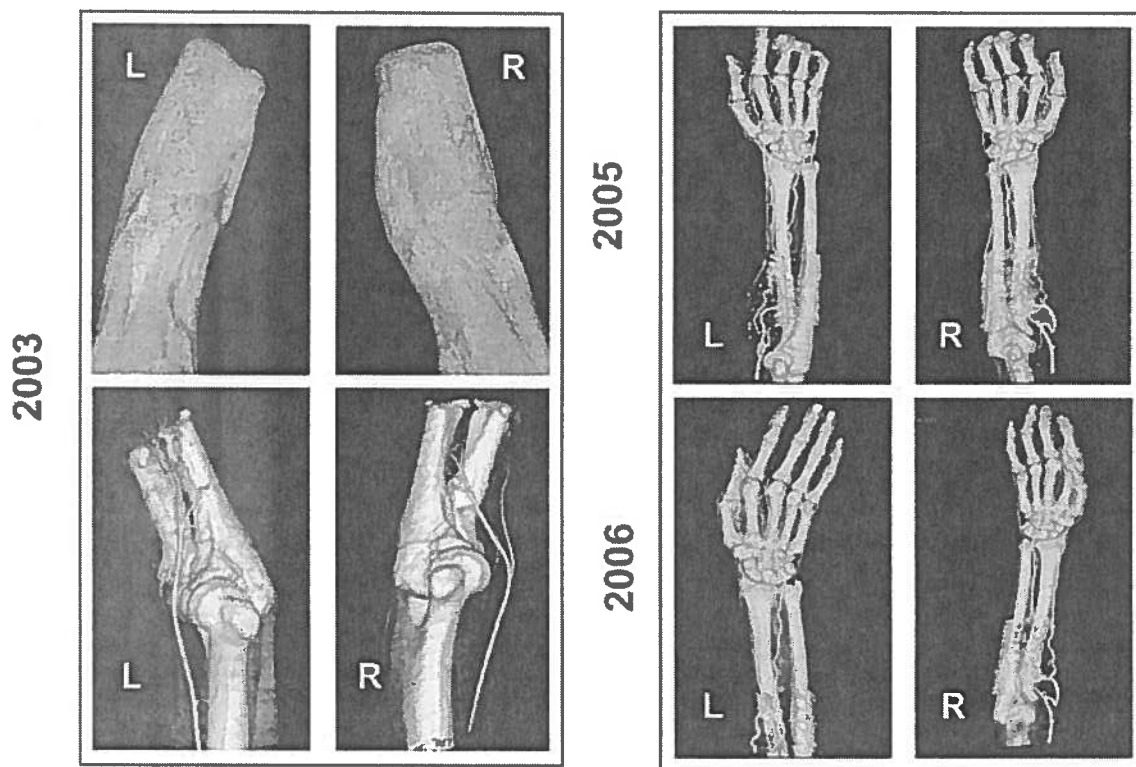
(2003) For CT angiography, 140 mL (5 mL/sec) of a non-ionic contrast medium was administered i.v. Smart Prep software (General Electric Medical Systems, Milwaukee, WI) was used to calculate scan delay. Volume rendering reconstructions after data were transferred to a three-dimensional rendering workstation (Advantage Windows 4.0; General Electric Medical Systems, Milwaukee, WI). Assessment of bone length, forearm muscles and vessels prior to transplantation revealed good vessel condition with sufficient caliber, but forearm muscles too short for reconstruction (2003). Investigations at 2 (2005) and 3 (2006) years after transplantation showed the radial, ulnar, and interosseous artery unchanged without any signs of luminal narrowing as indirect evidence of myointimal proliferation.
